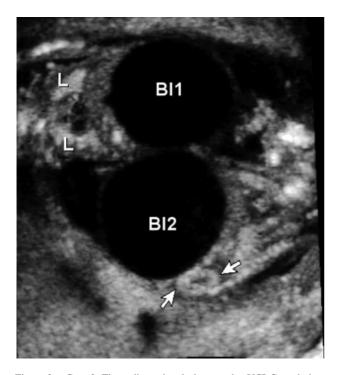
Case 2. Three-dimensional ultrasound—VCI-C rendering. The image shows a coronal view of both fetuses with severely dilated bladders (B11 and B12) and severe oligohydramnios. In the upper fetus, the lungs (L) and the heart in between are visible. In the lower fetus, the arrow indicates a hyperechoic dysplastic kidney
